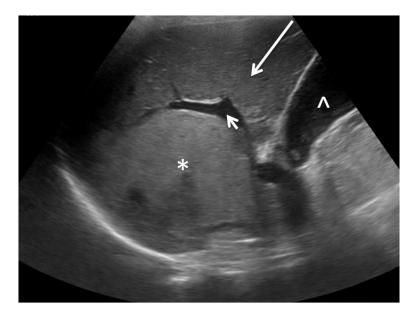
Longitudinal ultrasound image through the liver demonstrating landmarks including the diaphragm (bright line lower left of image), portal vein (short arrow) and stomach ($^{\land}$) as well as a heterogeneous right hepatic lobe mass measuring 8.9×7.7 cm (*), with the right lobe of liver (long arrow) being homogeneous in echotexture.
